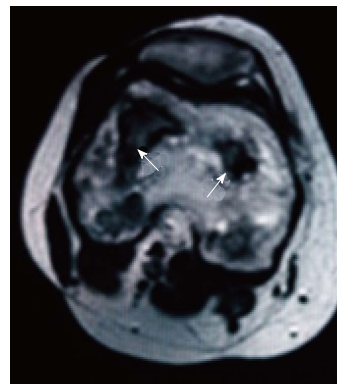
Magnetic resonance imaging (T2-weighted images, axial view) showing low signal serpiginous rims.
